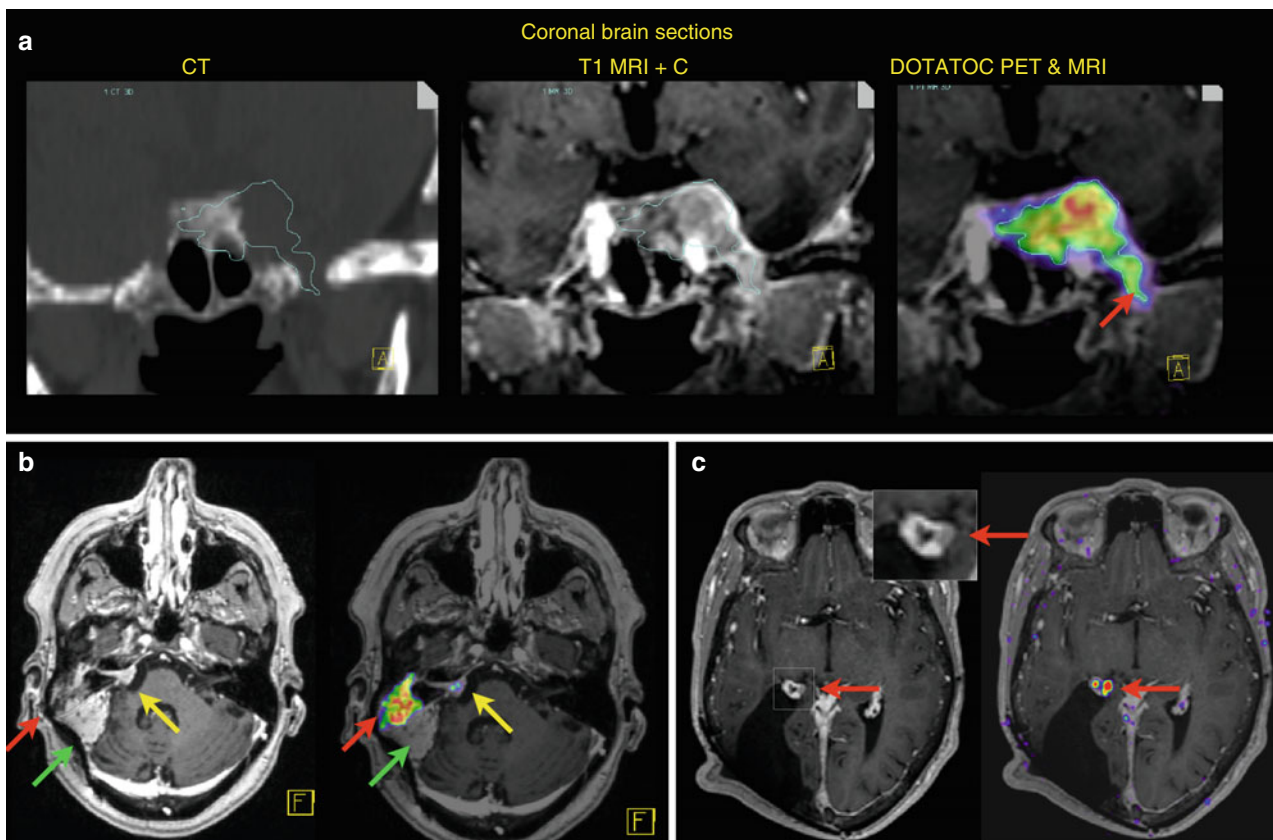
Examples of DOTATOC PET use in meningioma management. (a) *Recurrent meningioma (WHO I) referred for radiotherapy planning.* The patient suffered from trigeminal neuralgia and was treated without effect with dilation of the foramen ovale unaware that the tumour is infiltrating into the same opening (red arrow). Coronal CT shows an increased foramen ovale and tumour contours in blue. The tumour invading the ethmoidal sinuses is hard to delineate on post-contrast T1 MRI, but can easier be detected on DOTATOC PET scanning. (b) *Recurrent meningioma (WHO I) referred for radiotherapy planning.* Previous resection for a meningioma in the anterior right cerebellar hemisphere with fat tissue
